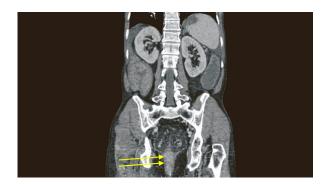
Distal rectum/anal canal stenosis on CT scan.
